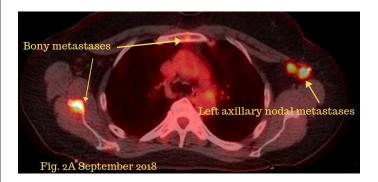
Increased FDG activity within the right scapula, sternum and left axillary nodes reflecting metastases pre-treatment.
